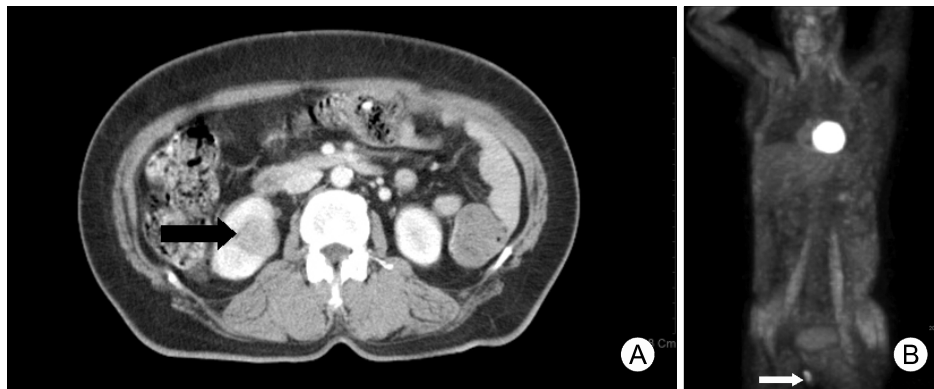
(A) CT image shows a $2.5 \times 2.5 \times 2.4 \text{ cm}^3$ sized round homogeneous hypodense lesion on the right kidney (arrow). (B) PET scan shows that focal increased FDG uptake is noted at external genitalia with the maximal SUV of 4.4 (arrow). No abnormal hypermetabolic lesion in other body portion including the right kidney is displayed. SUV; standardized uptake value.
